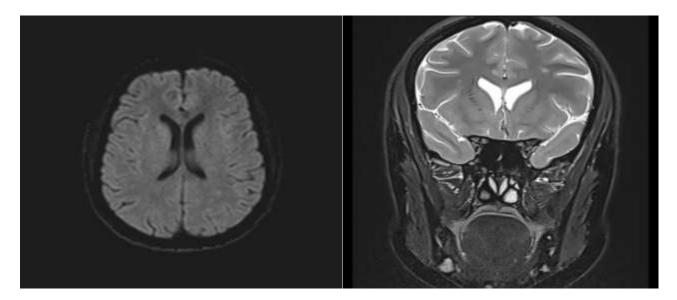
MRI: Magnetic resonance imaging of brain with contrast was done which showed T2W/FLAIR hyperintense non-enhancing signal in bilateral thalami extending caudally in mid brain on left side and in midline anterior medulla with subtle T2 hyperintense signal in body of corpus callosum, similar foci are seen in bilateral frontoparietal white matter suggestive of ADEM or demyelination. Also, T2 hyperintense signal in both optic nerves [left> right] in posterior part of orbit suggestive of optic neuritis.
